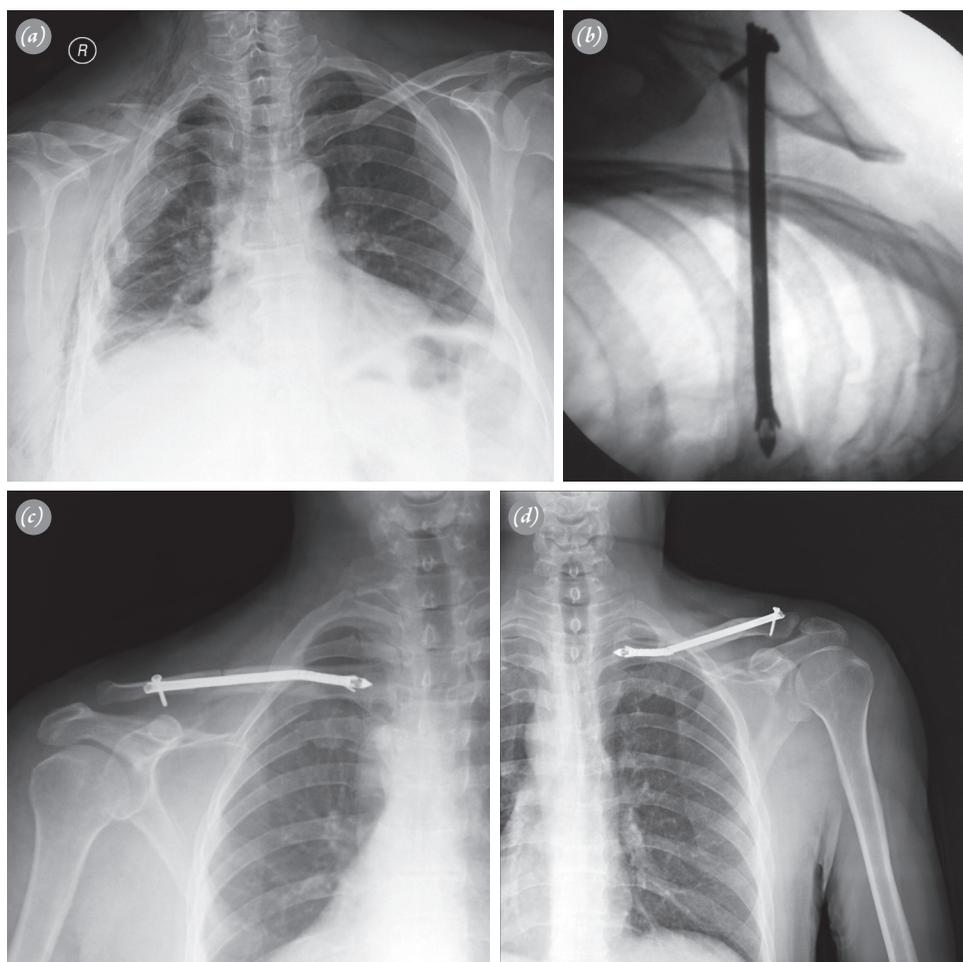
(a) Radiograph showing a midshaft clavicle fracture. (b) Perioperative fluoroscopy image for Type B2 clavicle fracture and (c) postoperative radiographic view. (d) Radiograph showing the broken elastic intramedullary nail.
